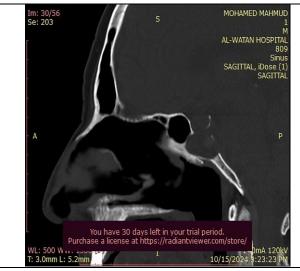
CT scan (sagittal view) shows opacity in the clivus with areas of hyperdencity and erosion of civus and sella.
